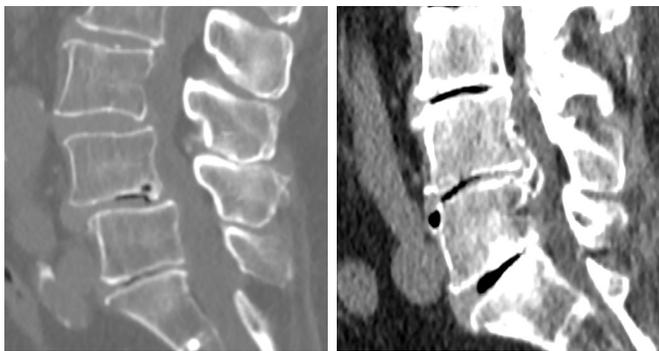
CT, sagittal view. Spondylolisthesis at the L3–L4 level, grade 1.
